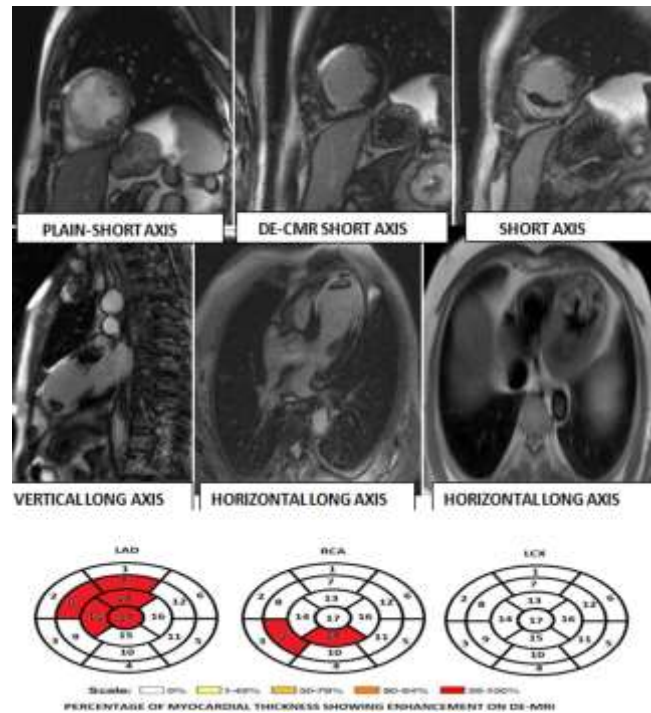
A 63-year-old male presented with chest pain and was diagnosed with Inferior wall MI with hypokinetic inferior wall, inferior IVS, posterior wall, and mild to moderate LV systolic dysfunction on 2D Echocardiography. Angiography showed LMCA WNL, LAD 50% RCA 90%, and LCX 50%. Plain and DE-CMR images in short axis and horizontal and vertical long axis views showing 75-100% of the myocardial thickness involvement in RCA territory involving the inferior wall, inferoseptal location in the midbody and base region. bulls eye plot showing transmural nonviable myocardium in the midbody and base region.
